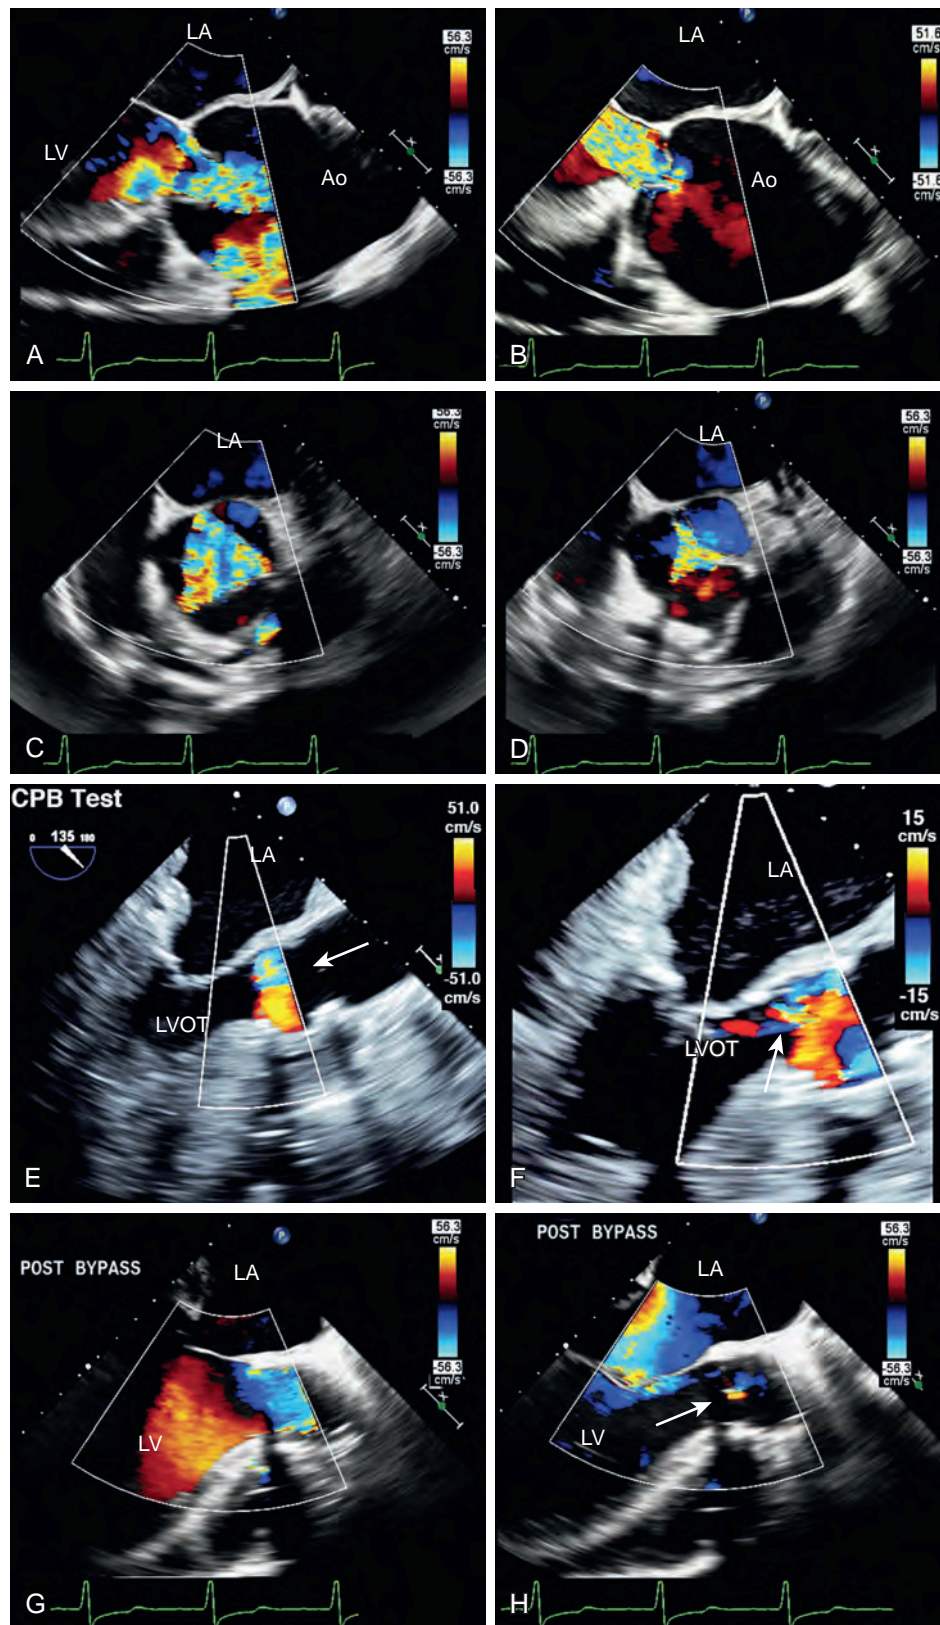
Aortic insufficiency (AI) and repair. (A–D) Prerepair color Doppler images from (A and B) long- and (C and D) short-axis windows depicting severe central AI. Images on the *left* are obtained during systole and those on the *right* are obtained during diastole. (E) and (F) were obtained during cardiopulmonary bypass, after repair of the aortic valve. Color Doppler imaging was used and the color scale was adjusted from 51 to 15 cm/s to increase the sensitivity of detecting residual AI. This is accomplished by infusing cardioplegia into the proximal aortic root under 80 mm Hg of pressure measured from the cardiopulmonary bypass (CPB) machine. (G) and (H) were obtained during a stable period after separation from CPB, during (G) systole and (H) diastole and shows trace AI. Ao, Aorta; LA, left atrium; LV, left ventricle.
